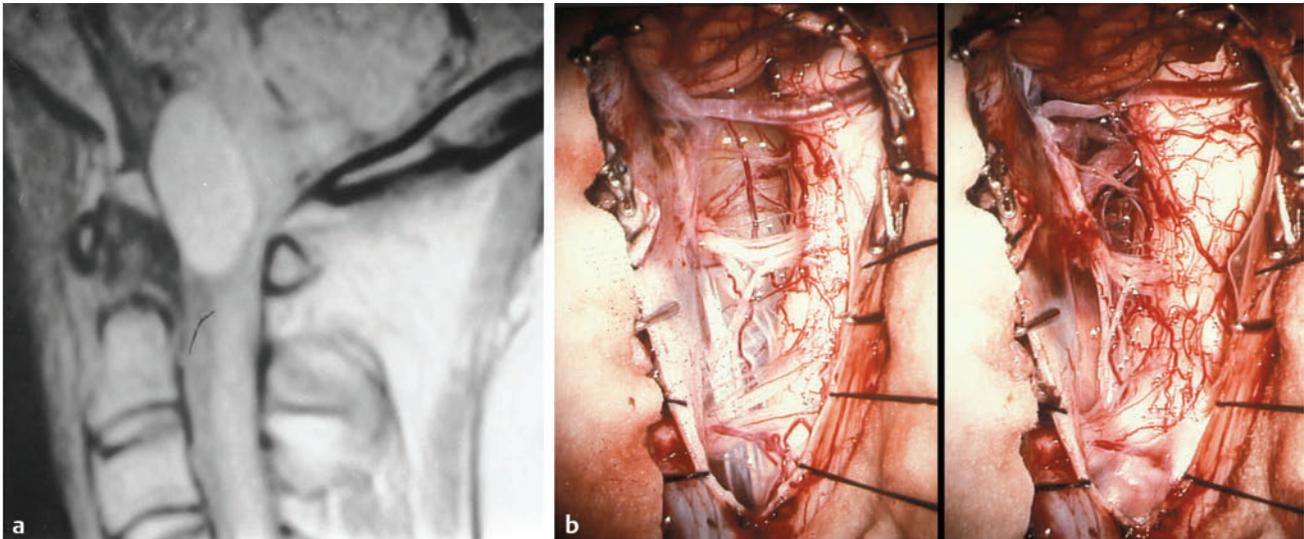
Neurenteric cyst. (a) The neurenteric cyst in this sagittal T1-weighted magnetic resonance image is typical in location (anterior to the cord) and signal characteristics (slightly hyperintense). (b) Intraoperative view of the anteriorly placed, well-defined neurenteric cyst, surrounded by the vessels and nerves of the upper cervical spine, before and after complete resection. (From Menezes AH. Tumors of the craniovertebral junction. In: Winn HR, ed. Youmans Neurological Surgery. 6th ed. Philadelphia, PA: W. B. Saunders; 2011:3114–3130.)
